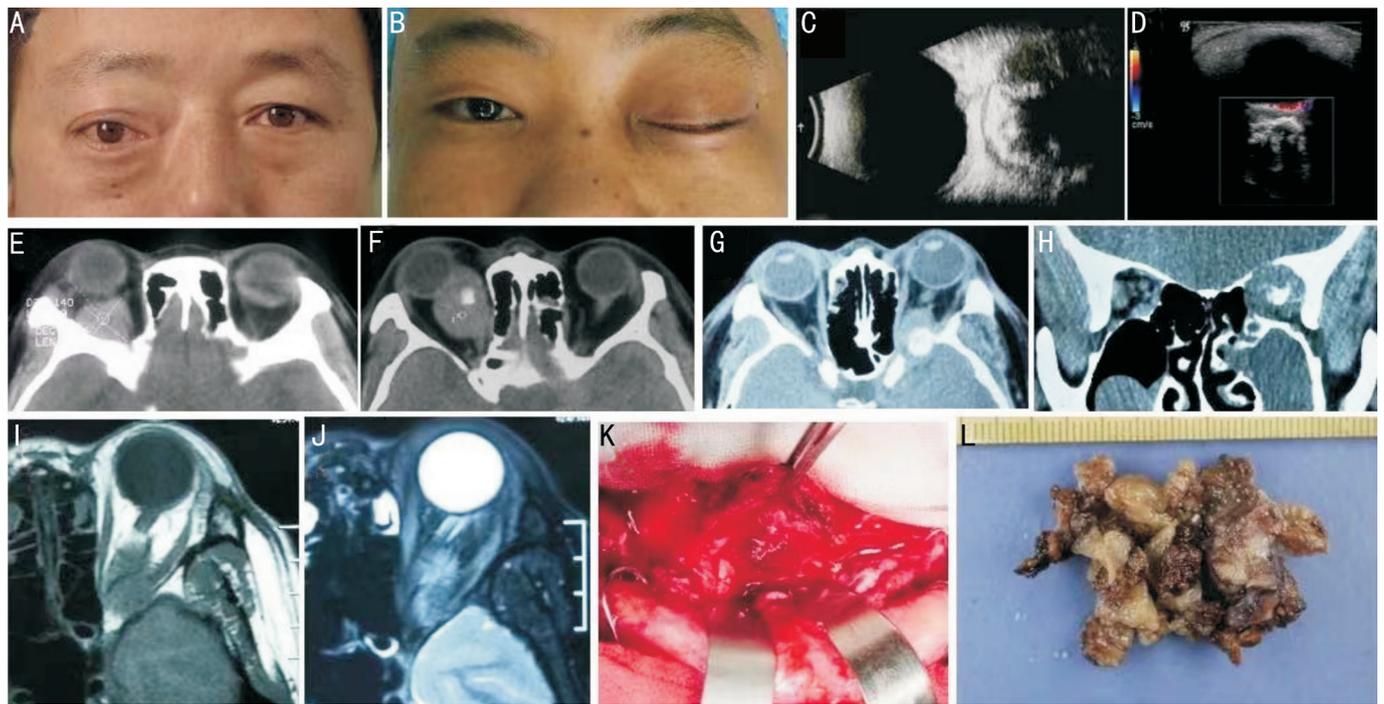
Clinical pictures of primary orbital MCS patients A: Clinical photos of case 2 showing proptosis and downward displacement of the right eye; B: Clinical photo of case 3 showing blepharoptosis and proptosis of the left eye; C: B ultrasonography of case 5 showing a well-delimited mass in the orbit; D: Color Doppler ultrasonography of case 3 showing a high speed and high resistance of blood flow; E: Axial CT of case 1; F: Axial CT of case 2; G: Axial CT of case 3; H: Coronal CT of case 3; I: Axial T1WI of case 3 showing the mass as isointense to grey matter; J: Axial T2WI showing heterogeneously isointense to hypointense-signal; K, L: Gross examination of case 3.
